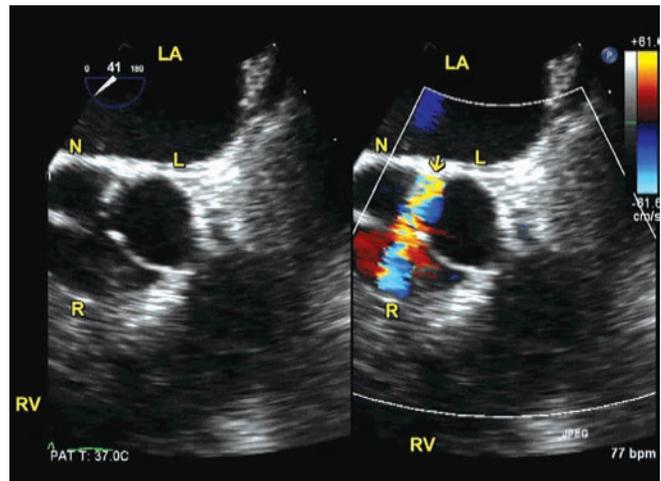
Transesophageal echocardiography. Arrow points to aortic regurgitation. L, N and R correspond to left, non and right coronary cusps of AV.
